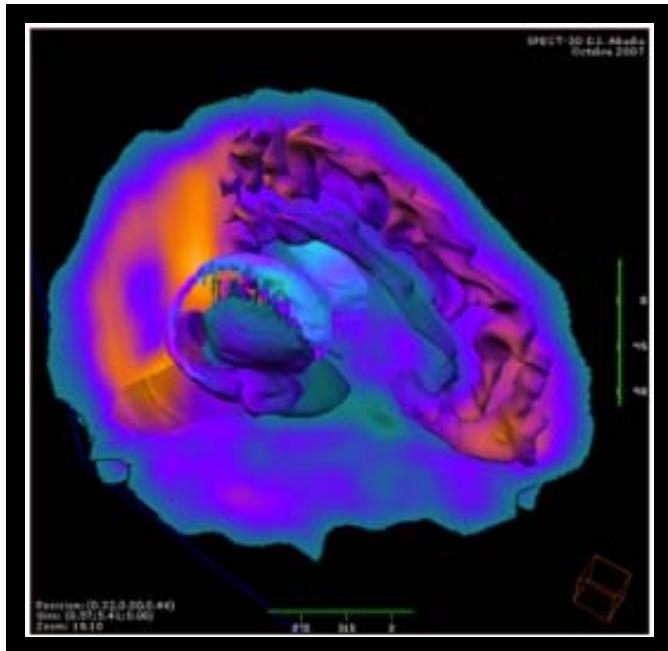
Anatomical functional viewer setting detail showing a representation of several brain structure 3D models embedded in SPECT sections. This integrated anatomical and functional visualization facilitates the comprehensive study of clinically relevant brain structures in major depressive disorder (hippocampus, amygdala, corpus striatum, cortical-medial region of a cerebral hemisphere).
